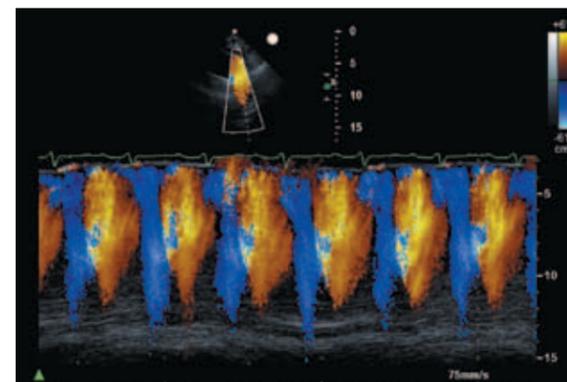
This colour Doppler M-mode trace displays pan-diastolic flow reversal in the descending aorta. This trace was acquired from the suprasternal long axis view with the M-mode cursor transecting through the descending aorta. Observe that blue flow (flow away from the transducer) occurs during systole (normal flow). The red flow within the aortic lumen (flow towards the transducer) commences at the beginning of diastole and continues throughout diastole (abnormal pan-diastolic flow reversal). Pan-diastolic flow reversal is an indirect sign of significant aortic regurgitation. M-mode is useful in this instance as the duration of flow may not be evident on the real-time colour flow Doppler image alone.
